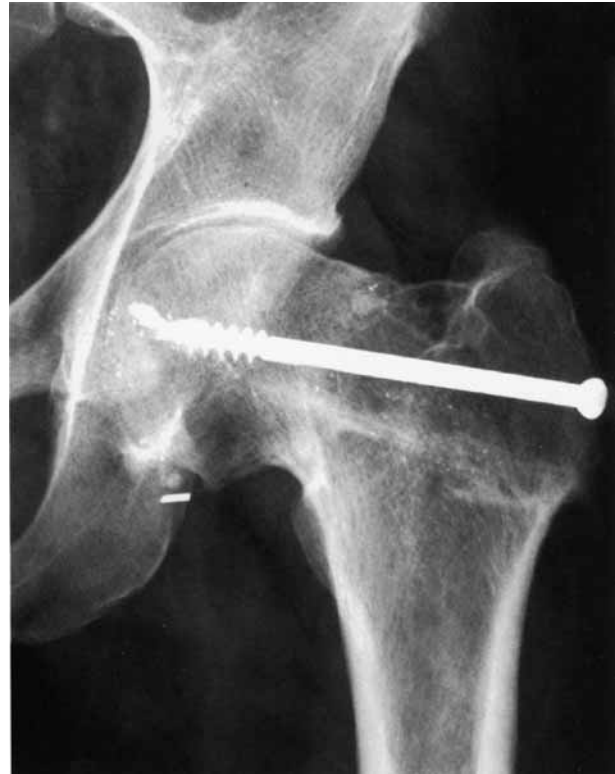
Radiograph of hip (AP view) showing two-third incorporation of the fibular graft, and passage of host trabeculae across the cortical bone, 7 years post surgery.
